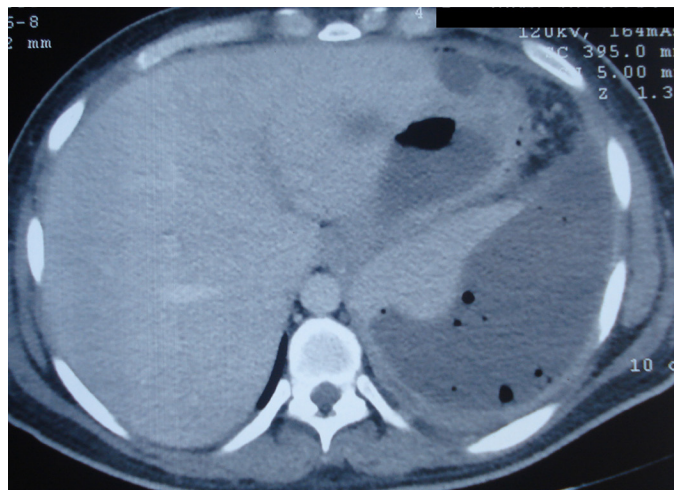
CT showing heterogenous pancreas, peripancreatic fluid and fat stranding.
